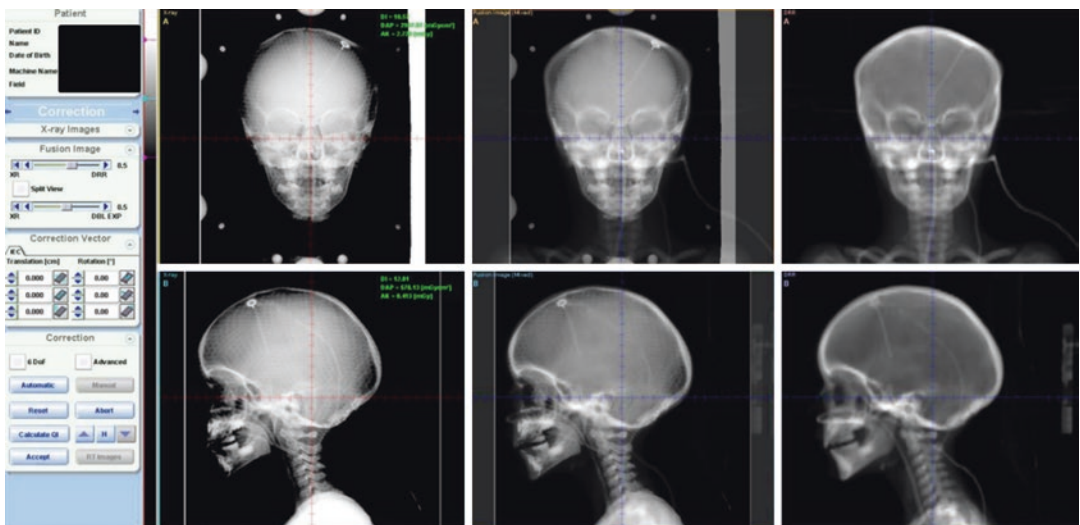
An example of electronic imaging portals. The daily portal is shown on the left, the digitally reconstructed radiograph is on the right, and the blended imaging is in the middle
